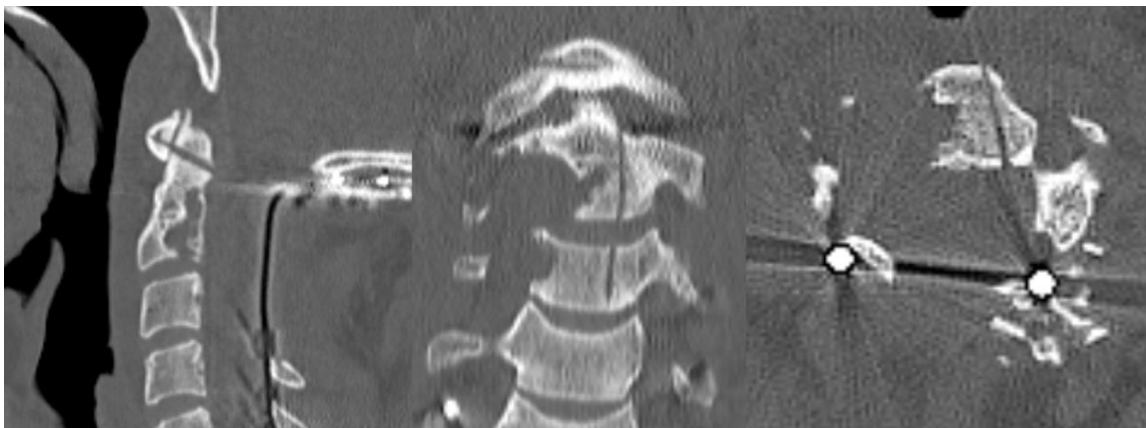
CT scan of the cervical spine showing osteotomy cuts performed via the posterior approach
